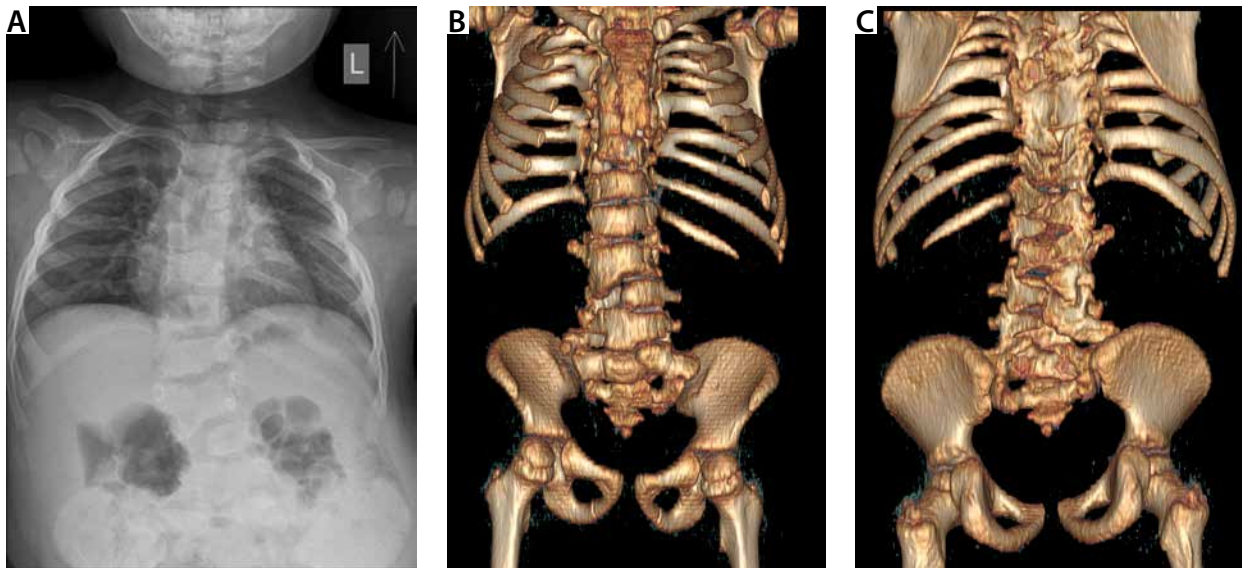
X-ray of the chest in the PA projection and 3D reconstruction of computed tomography – dextroscoliosis of the thoracic spine, numerous complex malformations of the spine, semi-vertebrae, and alternating bone blocks in the lumbosacral segment
